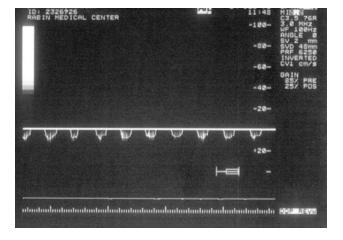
Doppler signals detected in the acardiac umbilical artery. Note shallow amplitude and absent end diastolic flow
